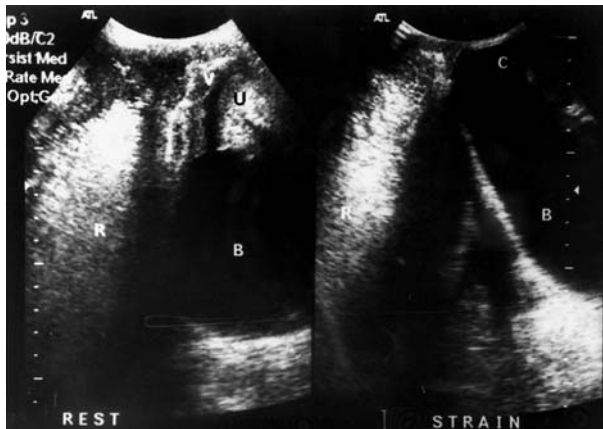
(ii).10. Sagittal dynamic transperineal ultrasound at rest and during straining showing a cystocele. The rectum (R), vagina (V), urethra (U), and the bladder (B) are well seen. At rest, the bladder is seen as an anechoic structure distended with urine with the urethra appearing as a hypoechoic channel. Posteriorly, the vagina is outlined by contrast and is seen as a hypoechoic line. The rectum is filled with echogenic contrast. During straining, the anterior part of the rectum moves anteriorly to form a small rectocele. The anechoic bladder prolapses downward to form a large cystocele (C). (Reprinted with permission from Beer-Gabel M, Teshler M, Barzilai N, Lurie Y, Malnick S, Bass D, and Zbar AP. Dynamic transperineal ultrasound in the diagnosis of pelvic floor disorders. Pilot study. *Dis Colon Rectum*. 2002;45:239–48.
